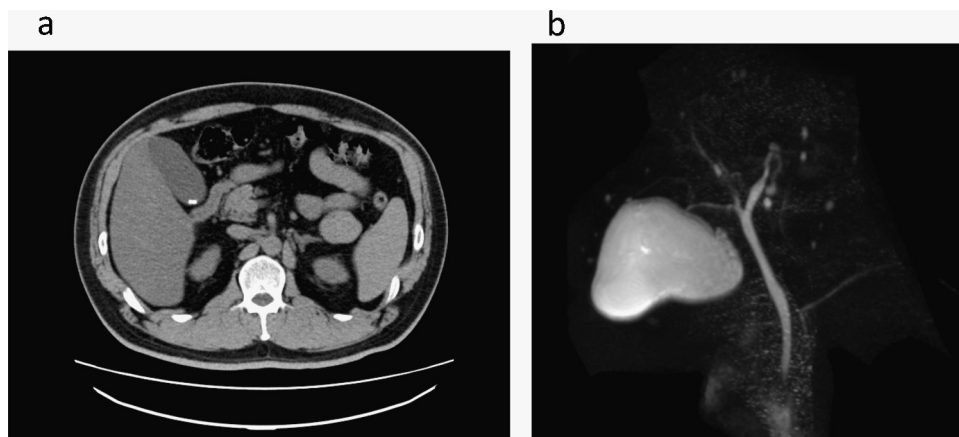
a. A CT image showing a high absorbance region in the neck of the gallbladder suggesting the presence of a stone. No thickening of the gallbladder wall or increase in the concentration of surrounding fat is evident. Fig. 2b MRI did not indicate an anomaly along the bile duct. The cystic duct branches from the middle portion of the bile duct, and a defect that suggests the presence of a stone in the common bile duct was not observed.
